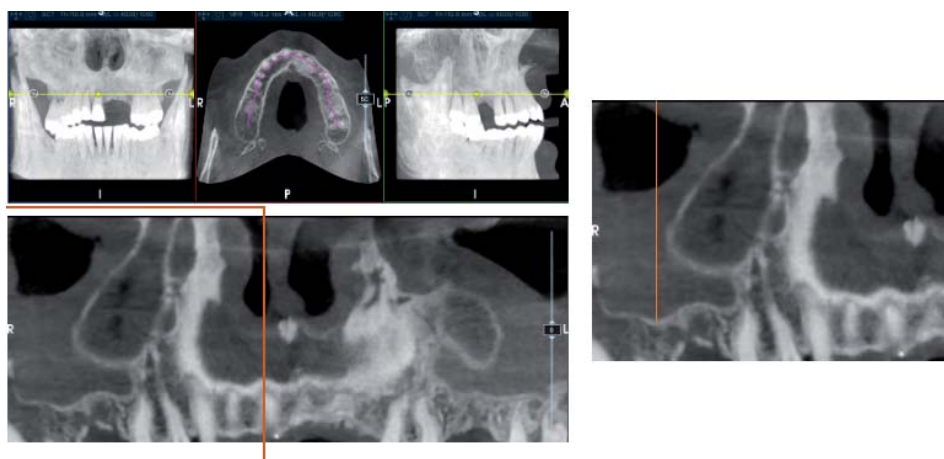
I CLASS: Mucosal thickening <2 mm CBCT of a patient. The arrow indicates the maximum mucosal thickness.
